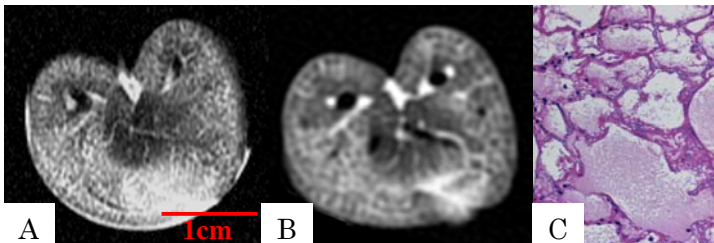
ARDS lung A) High-resolution SE image, B) corresponding CT, C) microphotograph (H-E). Fine reticular signal increase is demonstrated in the lung parenchyma, which corresponds to the pathological change on the microphotograph.
